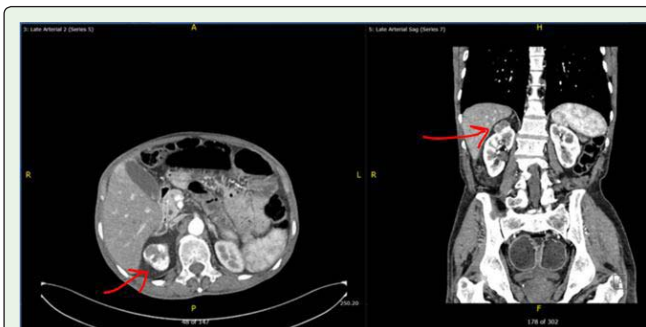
Abdominal computed tomography scan showed an exophytic mass in the upper pole of the right kidney.
